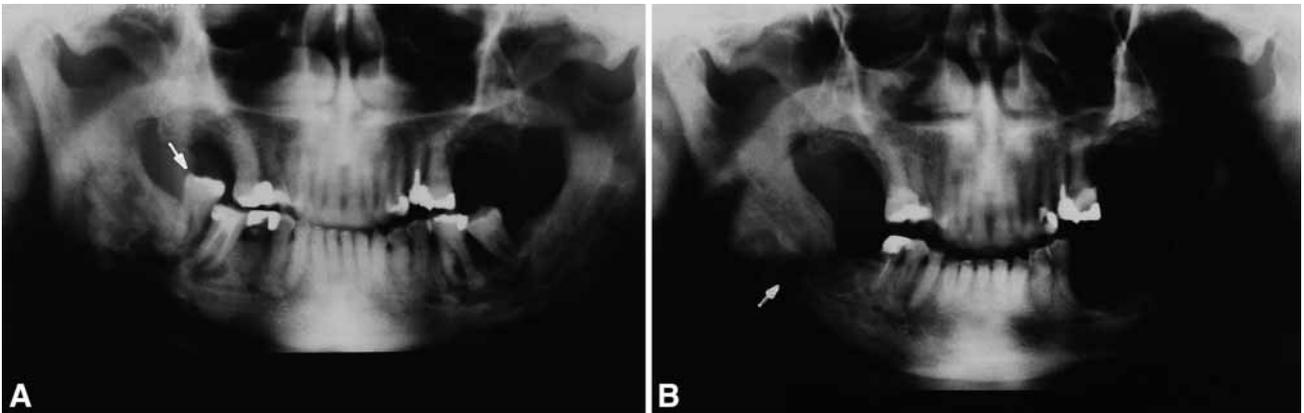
A.* Panoramic radiograph showing bilateral ORN of the body of the mandible, which developed from sites of periodontal disease activity. Note: white arrow points to upper level of right second molar tooth because of pathologic fracture of the mandible. *B.* Panoramic radiograph of healing mandible following surgery and HBO. Bony callous formation and healed fracture of the right body of the mandible (white arrow).
